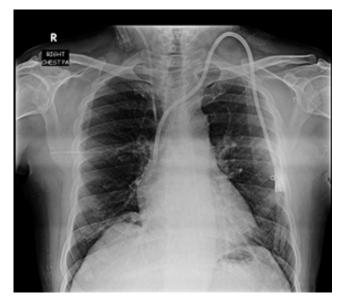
X-ray of chest showing retained guidewire.
